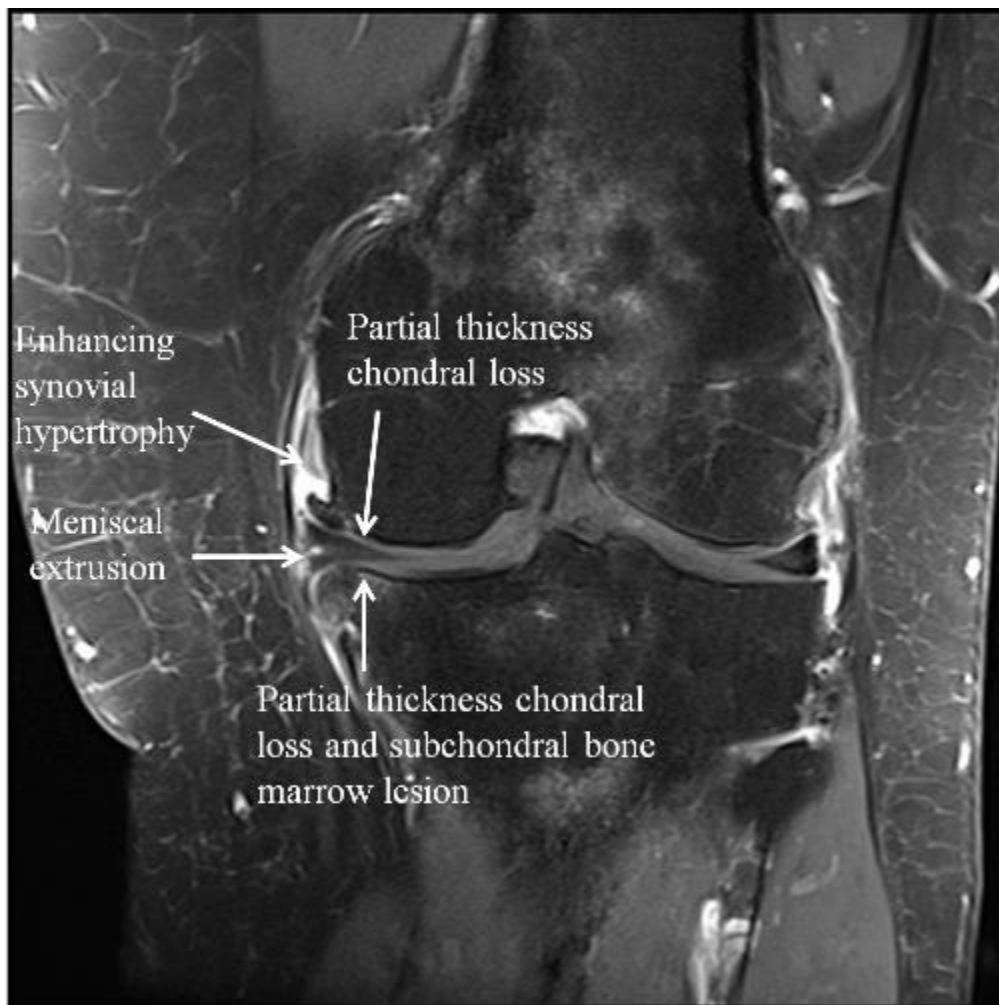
Coronal contrast-enhanced fat-suppressed T1 MRI of an osteoarthritic knee demonstrating partial thickness chondral loss towards the medial joint line involving the medial femoral condyle and medial tibial plateau, with small subchondral bone marrow lesions, moderate medial joint line osteophyte formation, meniscal extrusion and adjacent enhancing synovitis in the meniscofemoral recess.
